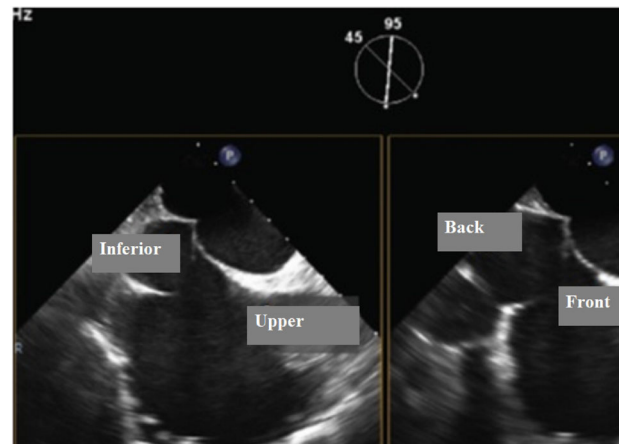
The TEE views of the transseptal puncture site. A, Inferior-and-low fossa position. AO, aorta; SVC, superior vena cava; TEE, transesophageal echocardiography [Color figure can be viewed at wileyonlinelibrary.com]
